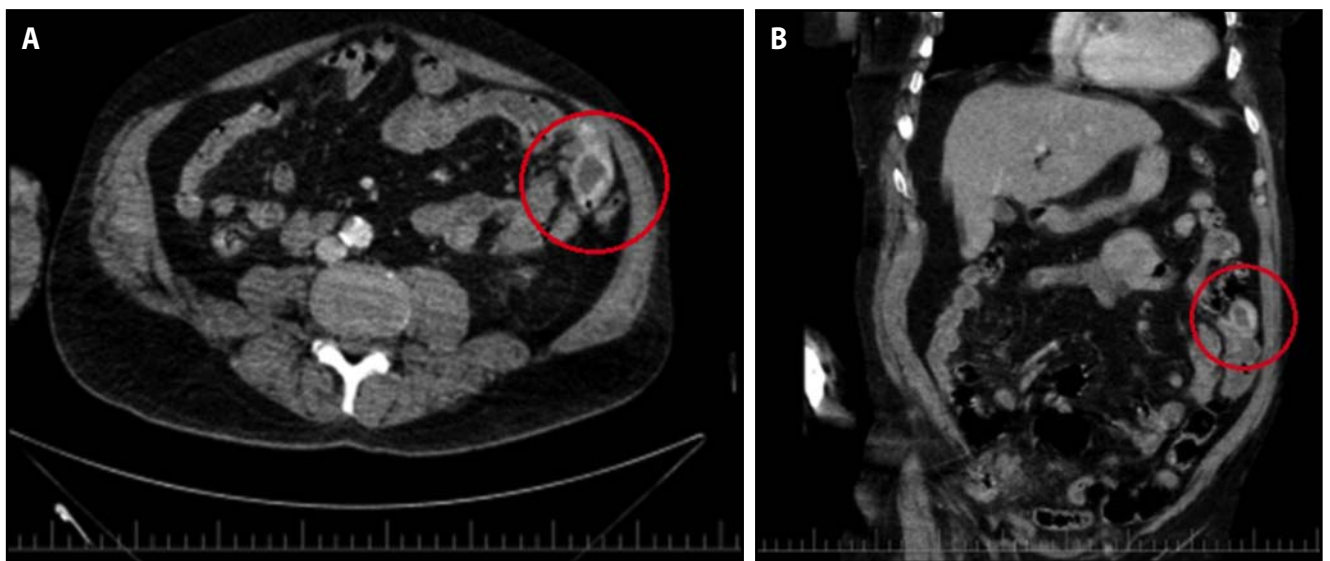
CT angiography, leak of the contrast from the jejunal region in the red circle:
